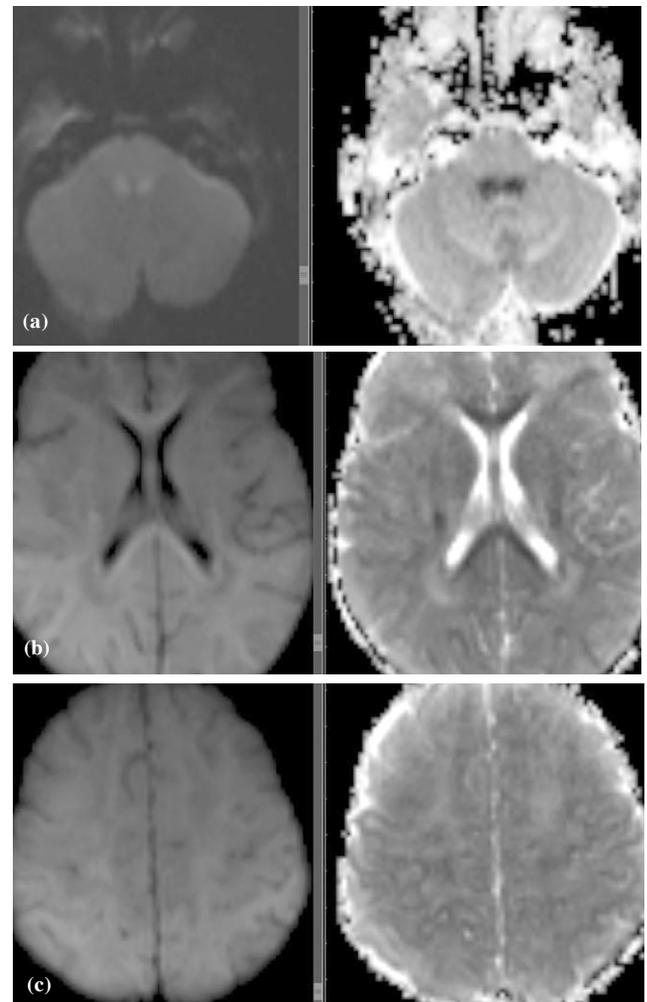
Axial DWI (B=1000) on the left side and ADC maps in the right side (a, b, c). On the 4th day after treatment, the areas showing diffusion restriction are seen to be regressed significantly.
